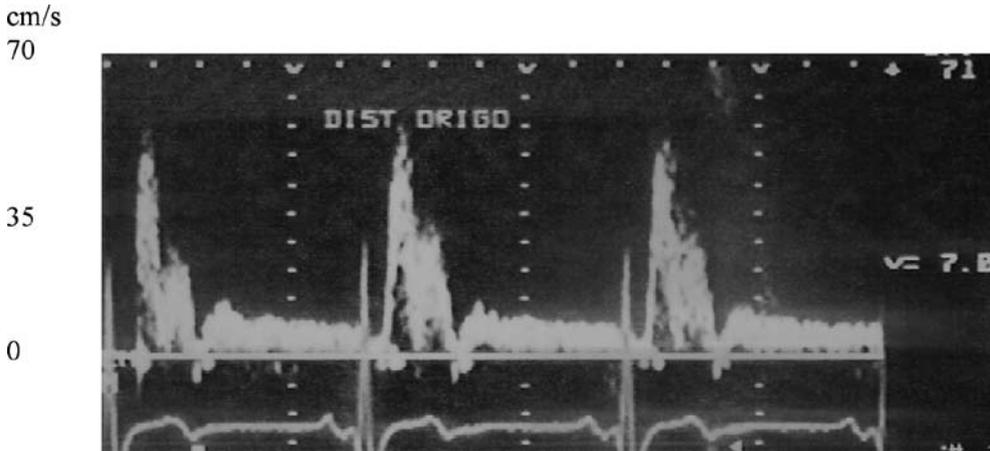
Preoperative supraclavicular ultrasound of the LIMA.
